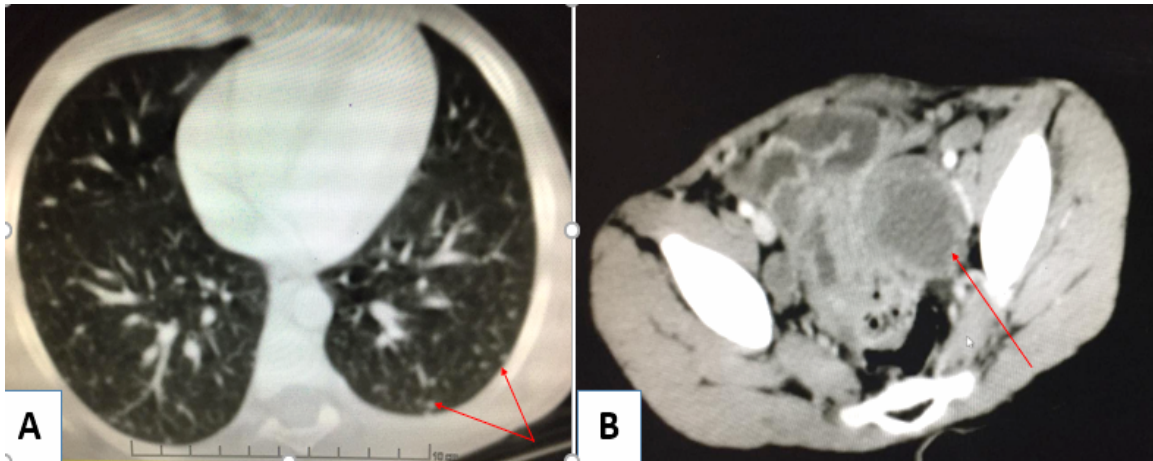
CT chest showing multiple small subpleural pulmonary nodules (A), CT pelvis showing multiple external and internal iliac Lymph nodes, the red arrow points to a large metastatic lymph node with central necrosis (B).
